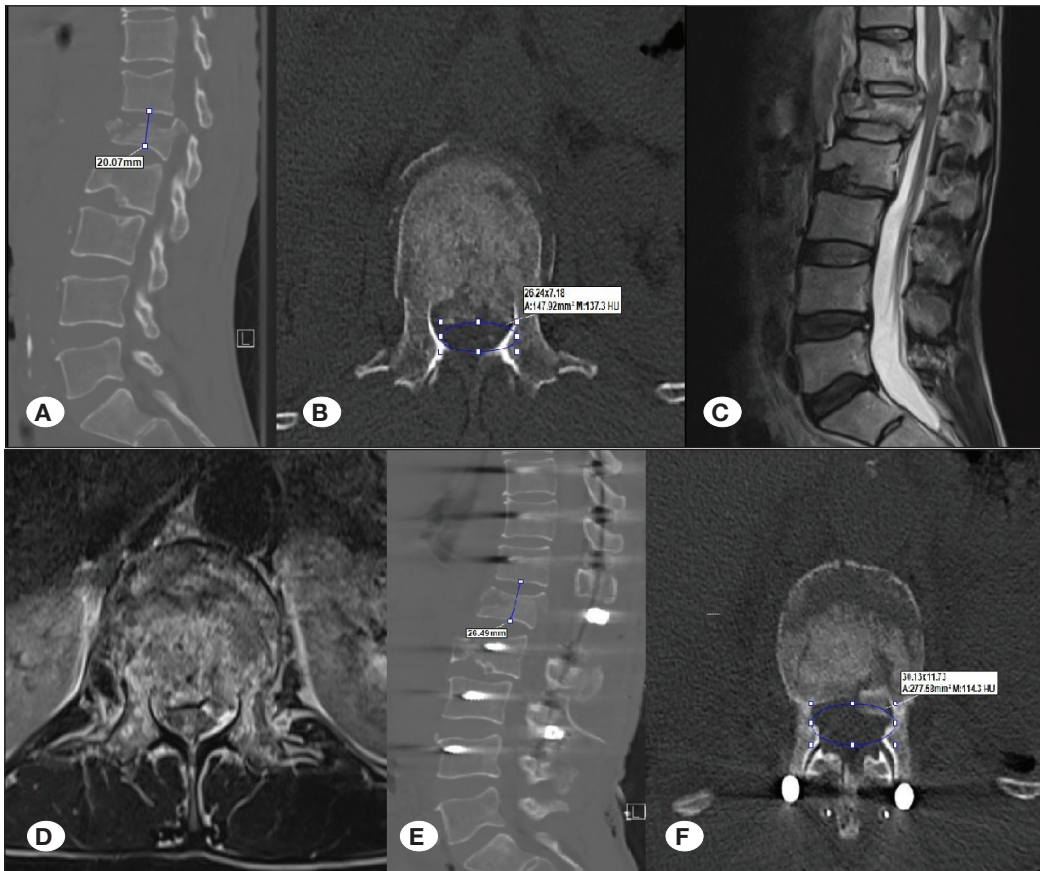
Preoperative sagittal computed tomography (CT) scan (A) showing the measurement of the fractured vertebral unit height, and axial CT scan (B) showing the spinal canal area at L1 burst fracture level. Preoperative sagittal (C), and axial (D) T2W magnetic resonance images showing spinal cord compression. Postoperative CT scans after posterior spinal instrumentation with distraction and ligamentotaxis showing apparent increase invertebral unit height (E) and widening of the spinal canal (F). The fractured vertebral unit height increased from 20.07 mm to 26.49 mm (+6.42 mm) (A,E), and the percentage of spinal cord compression decreased from 42% to 24% (+18%) (B,F).
